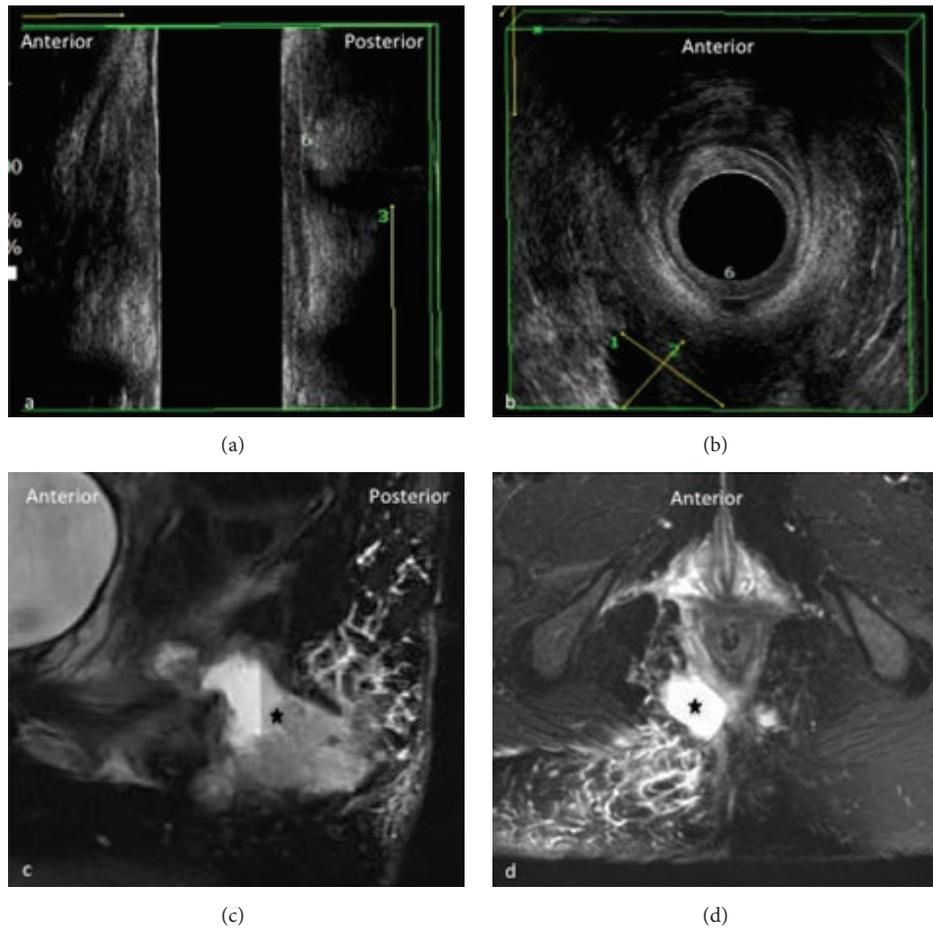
Extrasphincteric fistula at 6 o'clock with abscess. Sagittal (a) and axial (b) view of anal canal on 3D-EAUS showing at 6 o'clock (6) the proximal origin of an extrasphincteric fistula which drains into a big extrasphincteric abscess (calibers 1–3). On (c) and (d) sagittal and axial view, respectively, of anal and perianal region on MRI which is indispensable to demonstrate the complete extension of the extrasphincteric abscess (black star) and the appearance of edematous surrounding tissues.
